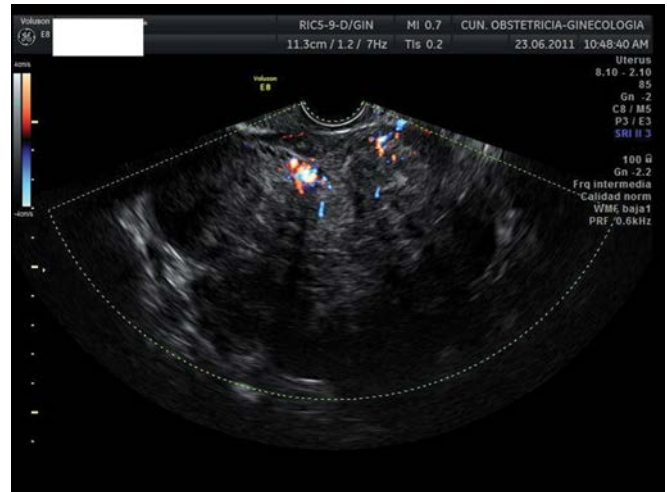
Transvaginal ultrasound in a 52-year-old woman who presented with pelvic pain and vaginal spotting. The mass is heterogeneous, and acoustic shadowings are present. A polymyomatous uterus was presumed. However, pathologic analysis after hysterectomy showed a leiomyosarcoma.
